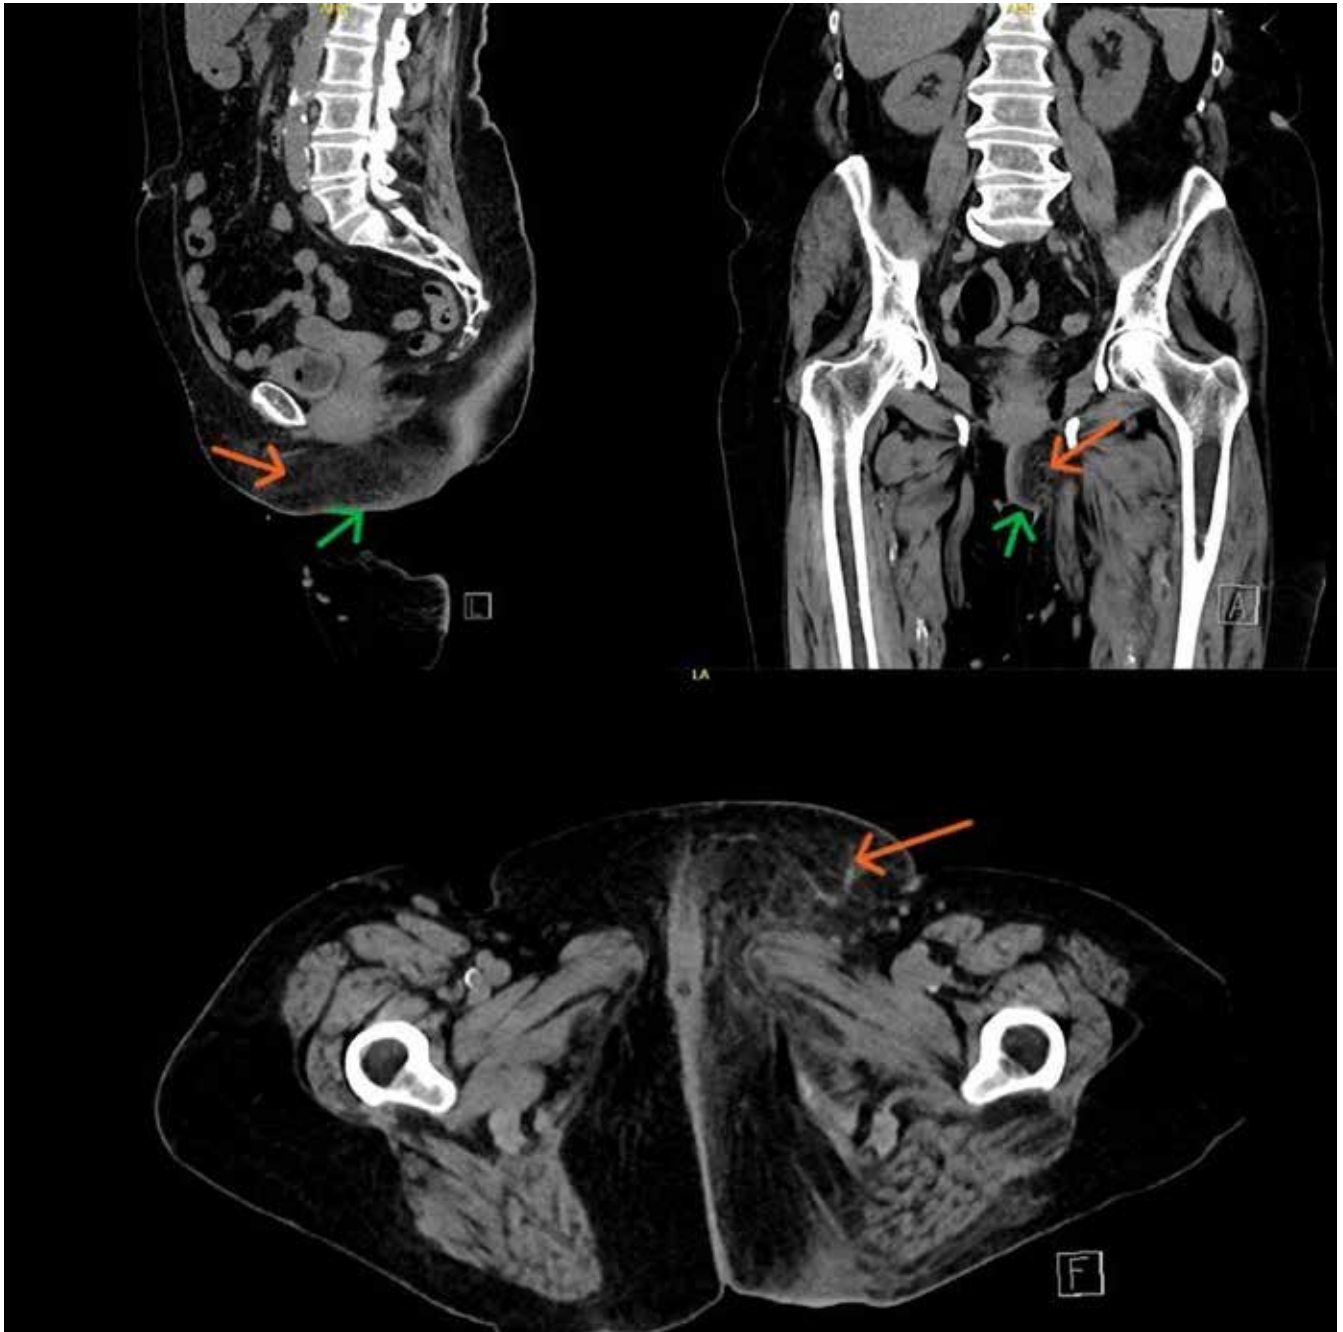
A CT scan of the pelvis and lower abdomen shows thickened skin (green arrows), structurally altered subcutaneous fat of the left mons pubis, left labia majora, and left perineum with minimal extension to the left gluteal area (orange arrows).
